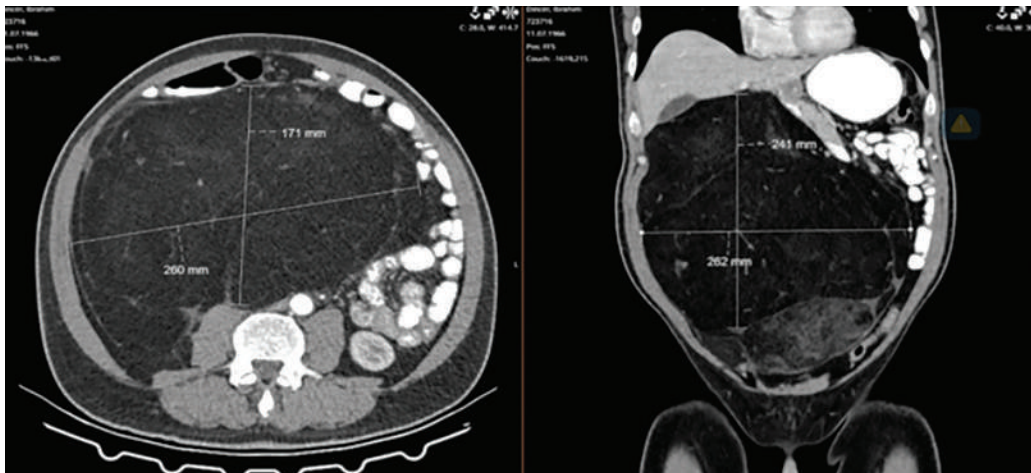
Axial and coronal section CT scan.
